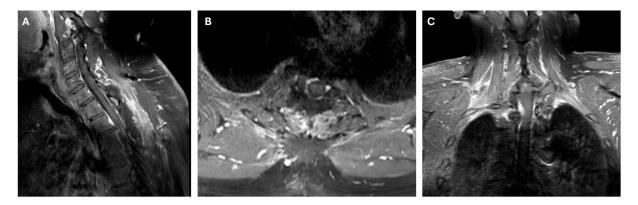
Postoperative cervicothoracic spine MRI. Sagittal (A), axial (B), and coronal T1-weighted images (C) with Gadolinium contrast from the one-month follow-up thoracic spinal MRI confirm the recent surgical resection of the intracanal, extradural expansile process at Th1 to Th3. This picture is from Garibaldi Hospital, Catania, Italy, and informed consent was obtained from the patient for this study.
